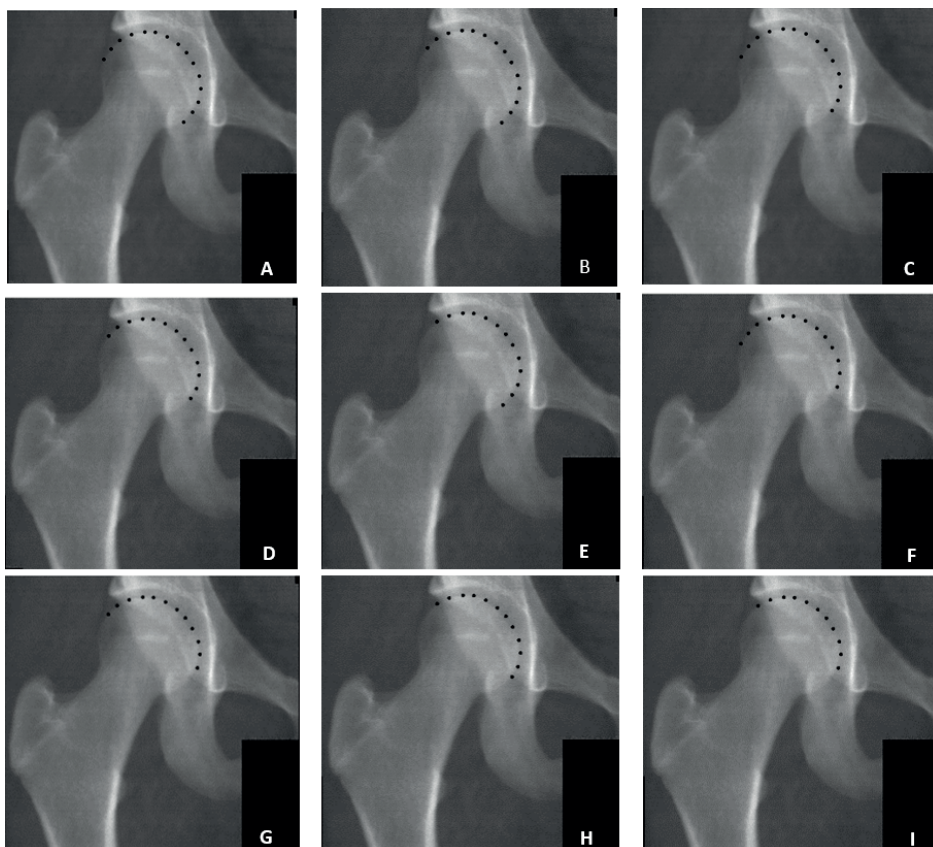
All possible combinations of radiographic landmark points used to define the best-fitting circle. A: All femoral head points. B: One point less on the lateral side of the femoral head. C: One point less on the medial side of the femoral head. D: One point less on both the lateral and the medial side of the femoral head. E: Two points less on the lateral side of the femoral head. F: Two points less on the medial side of the femoral head. G: One point less on the lateral and two points less on the medial side of the femoral head. H: Two points less on the lateral and one point less on the medial side of the femoral head. I: Two points less on both the lateral and the medial side of the femoral head.
